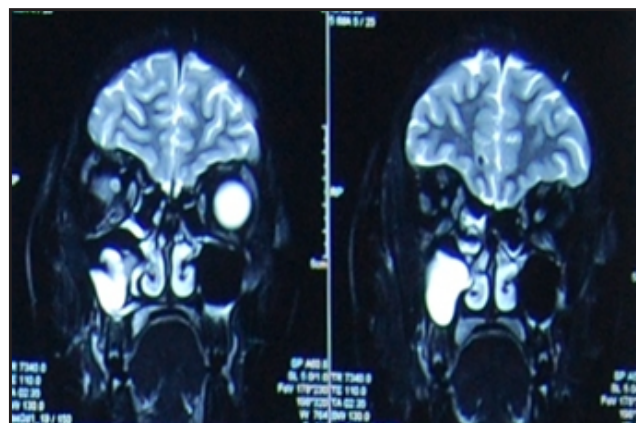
Coronal section of an MRI showing right maxillary sinus polyp/retention cyst (arrow).
